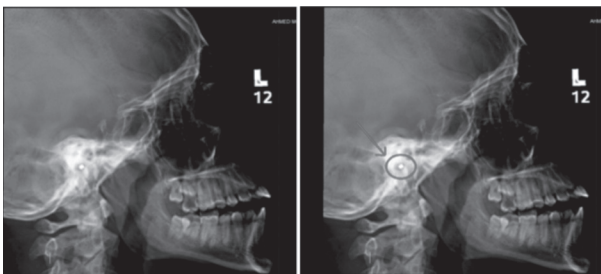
Lateral Skull X-ray Showing the Hearing Aid Device
